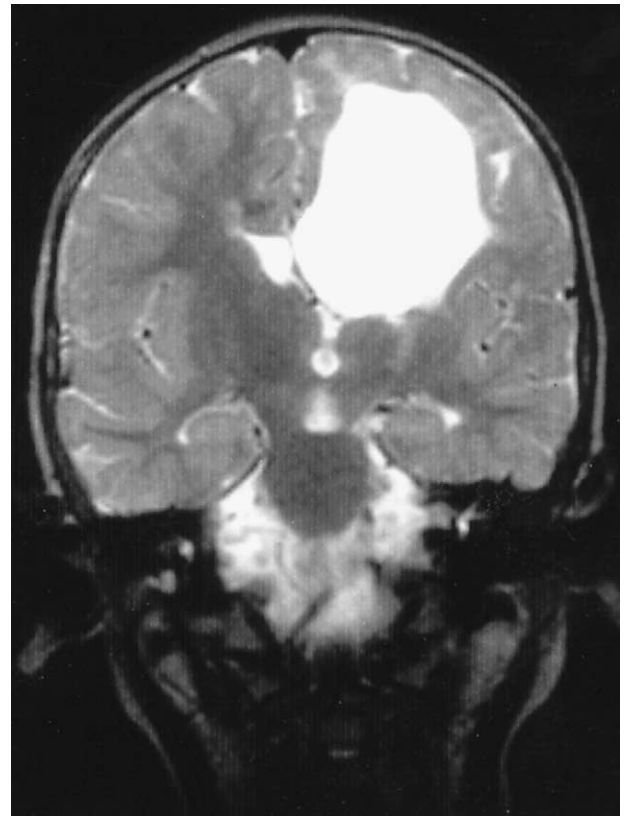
MRI (coronal section, T2 weighted) at 2 years of age. Porencephalic cystic dilatation of the left lateral ventricle with loss of subcortical white matter.
